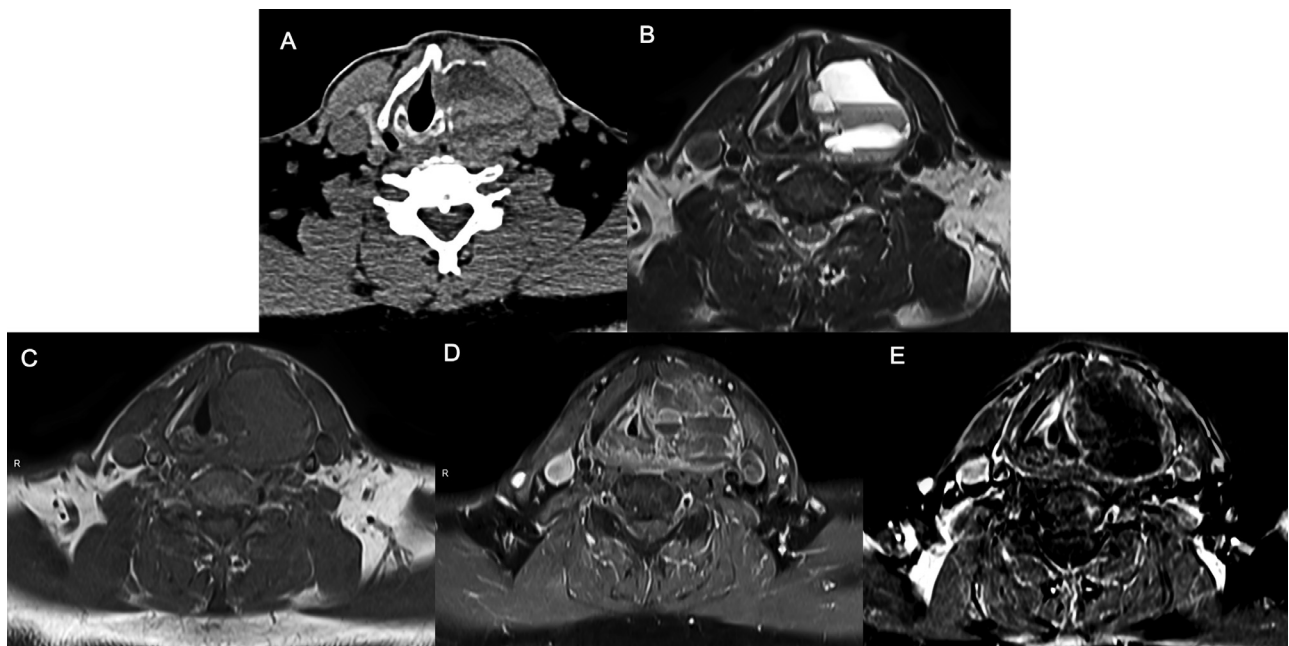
(A) Computed tomography (CT) showing left paralaryngeal mass inseparable from the thyroid cartilage lamina, with multiple fluid levels. (B) T2-weighted Magnetic resonance imaging (MRI) provides a better view of the solid-cystic appearance and the extent of the lesion involving the thyroid cartilage. (C) Precontrast T1-weighted MRI shows an intermediate signal lesion; (D) Postcontrast T1 and (E) Postgadolinium T1 with subtraction: left paralaryngeal mass with subtle peripheral enhancement and septal enhancement.
